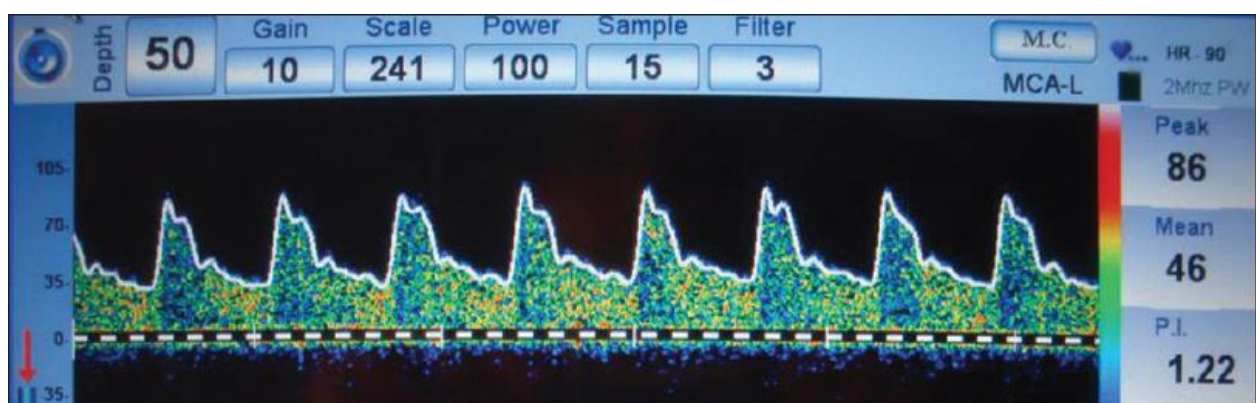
Transcranial Doppler Signal Acquisition. The transcranial Doppler waveform showing [the] middle cerebral artery, identified by the characteristic tracing in [the] upward direction<sup>(30)</sup>.
